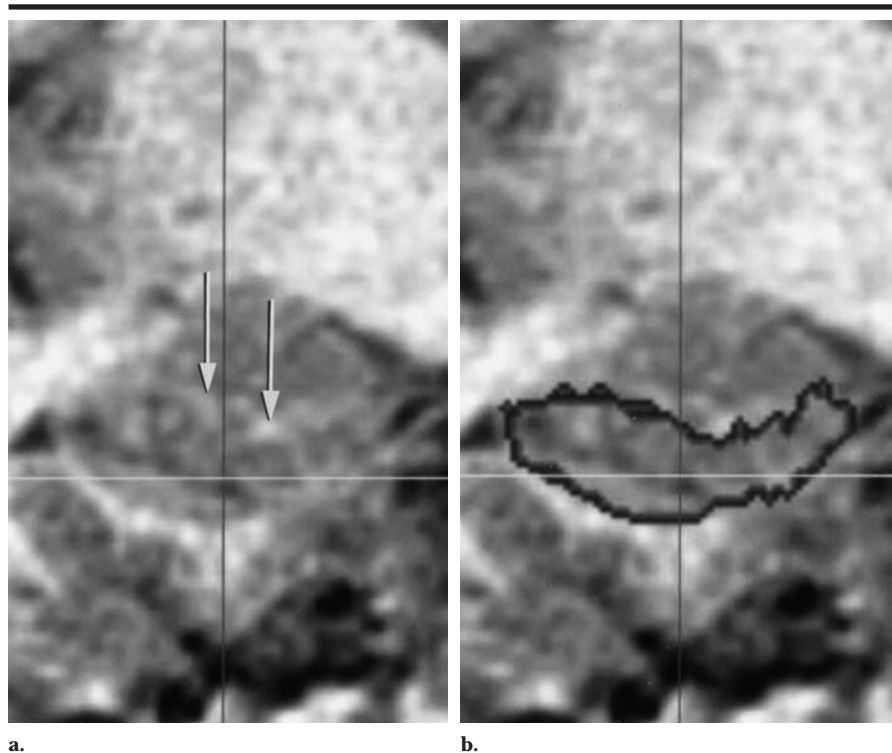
Patient 3. (a) Coronal fast spoiled gradient-recalled MR image (14/3, flip angle of 30°) through the head of the right hippocampus. The alveus (arrows) is visible, especially in the mesial aspect of the hippocampal-amygdaloid complex. (b) The same section as in a, with superimposed manual segmentation (black outline) of the hippocampus. The alveus was excluded from the segmentation. In this example, the alveus was visible and therefore helped define the superior border of the hippocampal head in this region.
